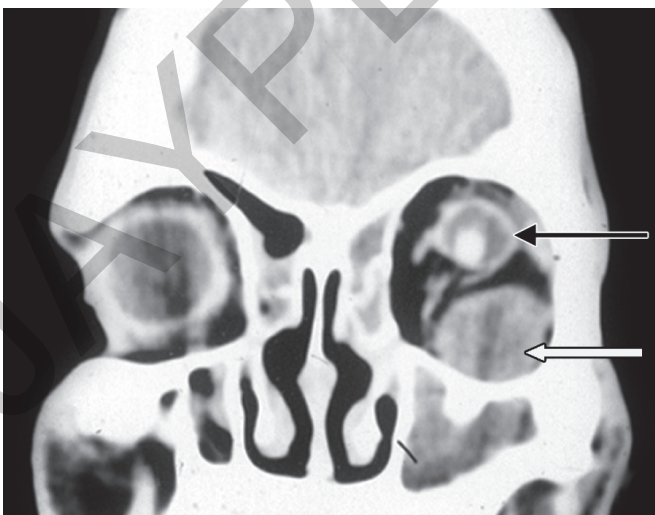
Coronal CT orbit showing small left globe (arrow) with calcified lens and an inferior orbital colobomatous cyst (block arrow) displacing the globe superiorly
